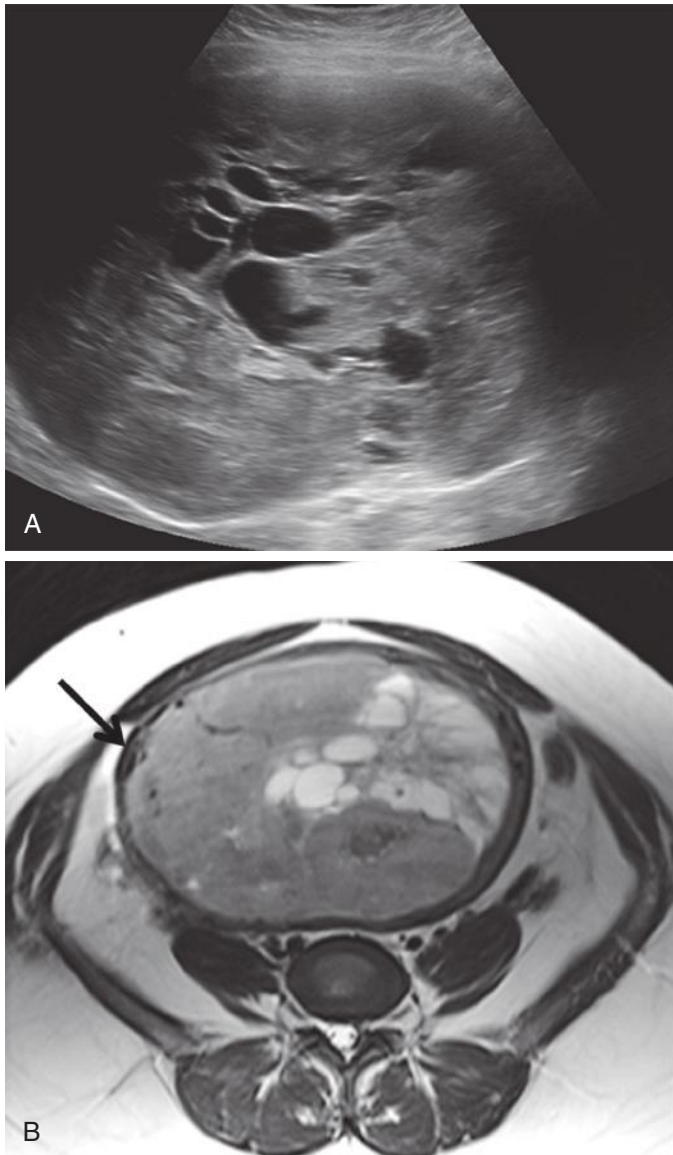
Cellular leiomyoma with imaging features concerning for leiomyosarcoma. A, Ultrasound image demonstrates a large dominant mass with irregular, indistinct borders and areas of cystic change within the uterus. B, Axial magnetic resonance image demonstrates areas of heterogeneity and increased T2-weighted signal, consistent with necrosis/cystic change. There was questionable invasion of the myometrium (arrow). However, benign cellular leiomyoma was found at myomectomy.
